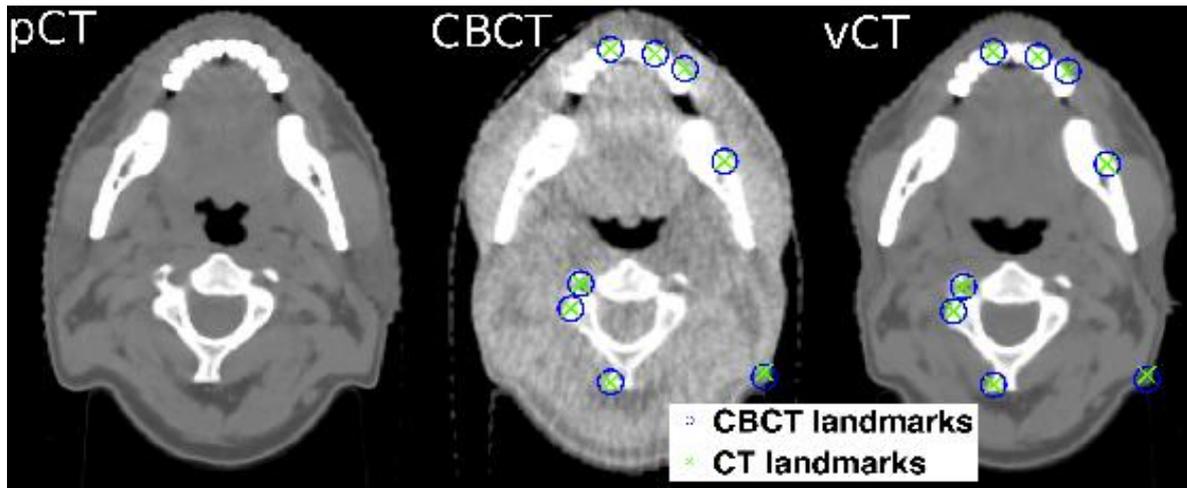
Comparison of pCT, CBCT and vCT for a late treatment fraction. The corresponding features (crosses and circles) between the CBCT and vCT obtained from aSIFT are presented for a typical slice.
